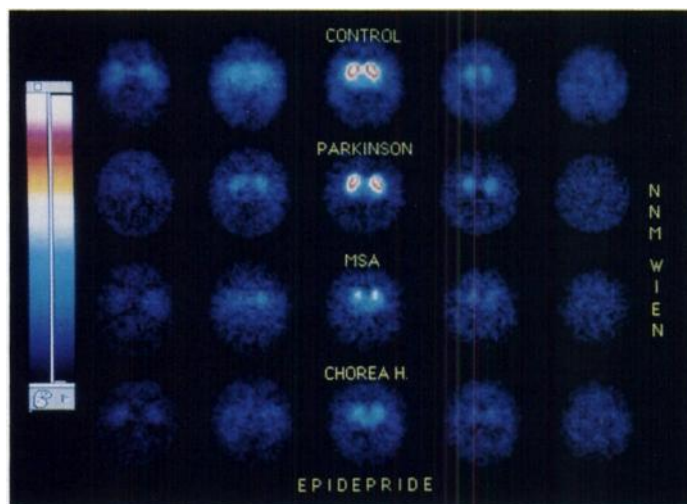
Iodine-123-epidepride-SPECT 3 hr postinjection in a control subject, a patient with Parkinson's disease, a patient with striatonigral degeneration (MSA of SND-type) and a patient with HD demonstrating normal striatal epidepride binding in the patient with Parkinson's disease and reduced binding in patients with MSA and HD. The four images are scaled to the maximum of the control. Axial SPECT-images (3.5-mm thick), each shifted by 17.5 mm beginning at the level of the cerebellum (left images). Maximal striatal binding is displayed on the middle images.
